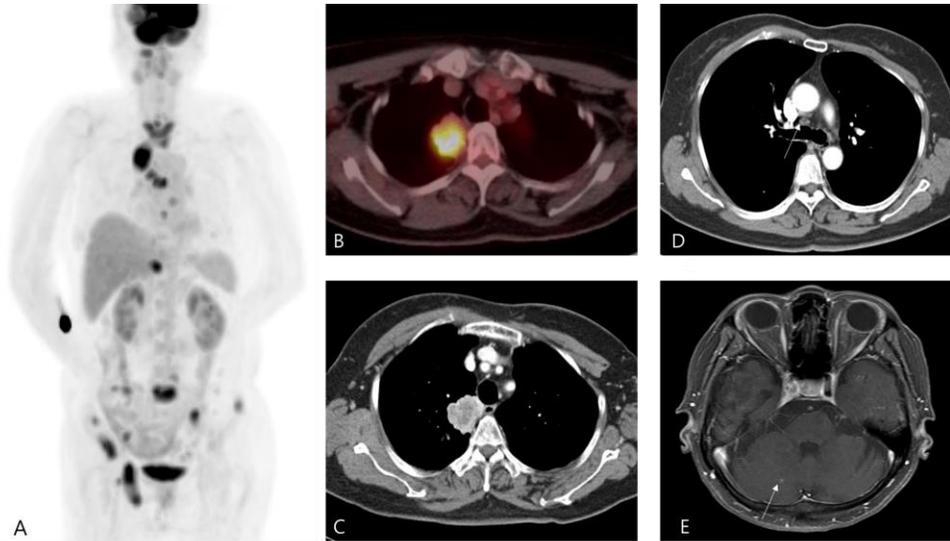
Representative case of extrathoracic metastasis detected on F-18 FDG PET/CT. Sixty five-year-old female patient with right upper lobe lung adenocarcinoma. CT showed 3.4x3.2cm well enhancing mass with central necrosis and enlarged hilar lymph node (stage T_{2a} N₁ M₀). PET/CT demonstrated hypermetabolic mass in the right upper lobe (SUV_{max} 13.5), right hilar lymph node (SUV_{max} 3.5) and multiple hypermetabolic bone lesions in the rib, thoracic vertebra, sacrum, both iliac, right acetabulum, right ischium and right femoral head (stage T_{2a} N₁ M₁). Axial T1-weighted post contrast MRI showed enhanced nodule in the right cerebellum which considered as brain metastasis.
